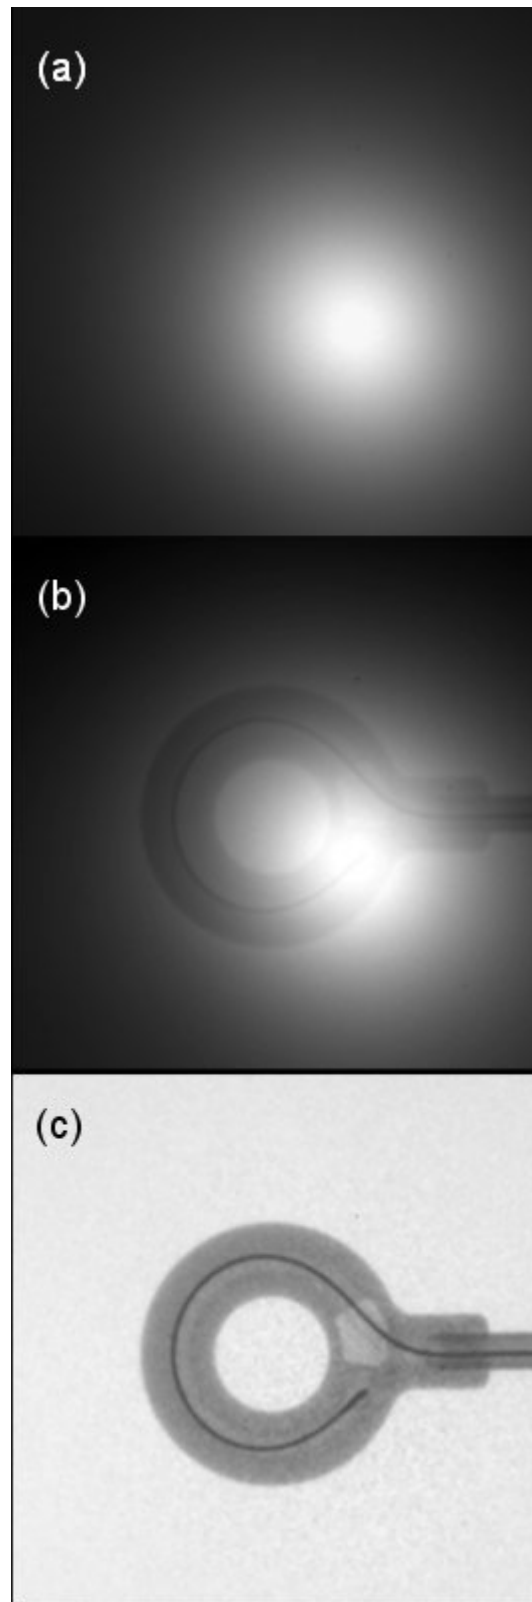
(a) Autoradiograph (source radiation) captured by the FPD. (b) Simultaneous external x-ray exposure and source
